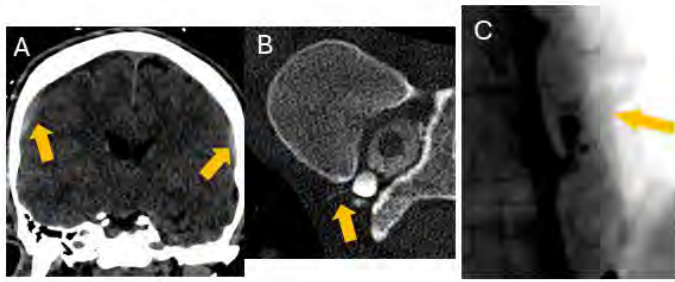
A 56-year-old patient was found down. (A) Coronal head CT demonstrates bilateral subdural hematomas. Brain MRI (not shown) demonstrated prominent brainstem sagging. (B) Right lateral decubitus photon counting CT myelogram demonstrates suspicious curvilinear contrast (arrow) arising from the right T10-T11 neural foramen. (C) Subsequent right lateral decubitus DSM confirms an outpouching of contrast opacifying right paraspinal veins, consistent with a CSF-venous fistula (arrow).
